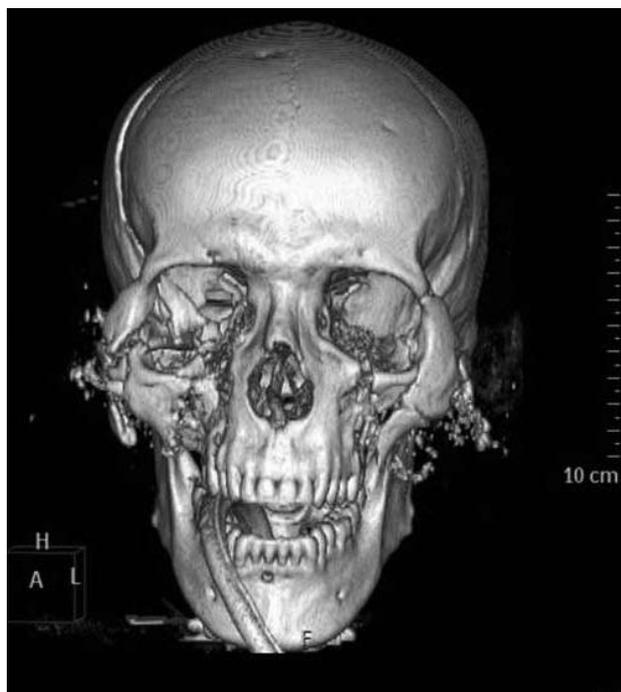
3 D CT of high energy exchange damage to midface from a high velocity round.
